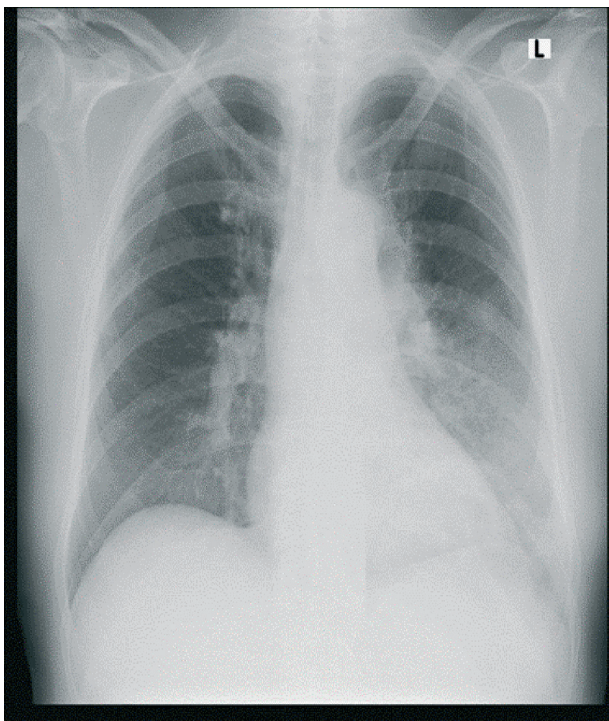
Chest X-ray on hospital admission. Large infiltrate in the left lower lung with incipient pleural effusion
